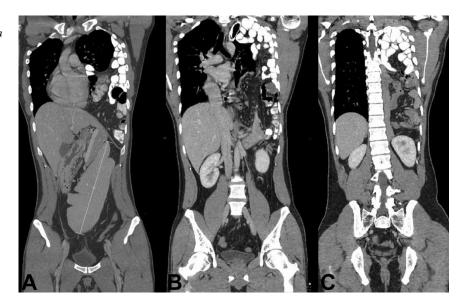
Computed tomography scan of (A) chest, (B) abdomen, and (C) pelvis showing a large diaphragmatic hernia.
